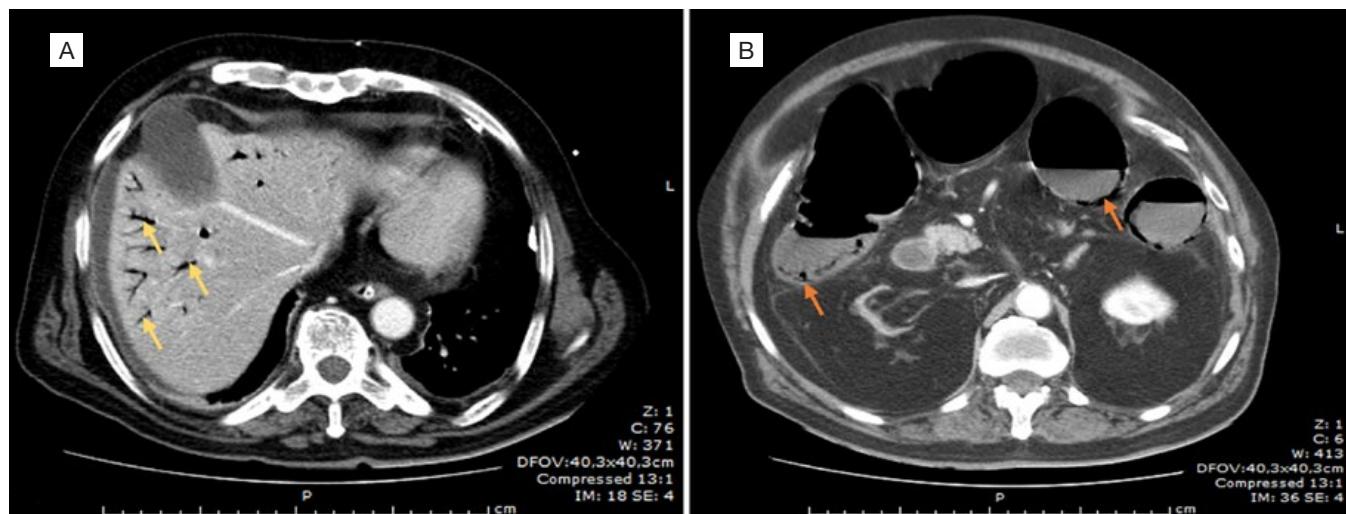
Panel A: Abdominal CT showing aeroportia (yellow arrows). Panel B: pneumatosis intestinalis (orange arrows) with air-fluid levels in distended loops of bowel
